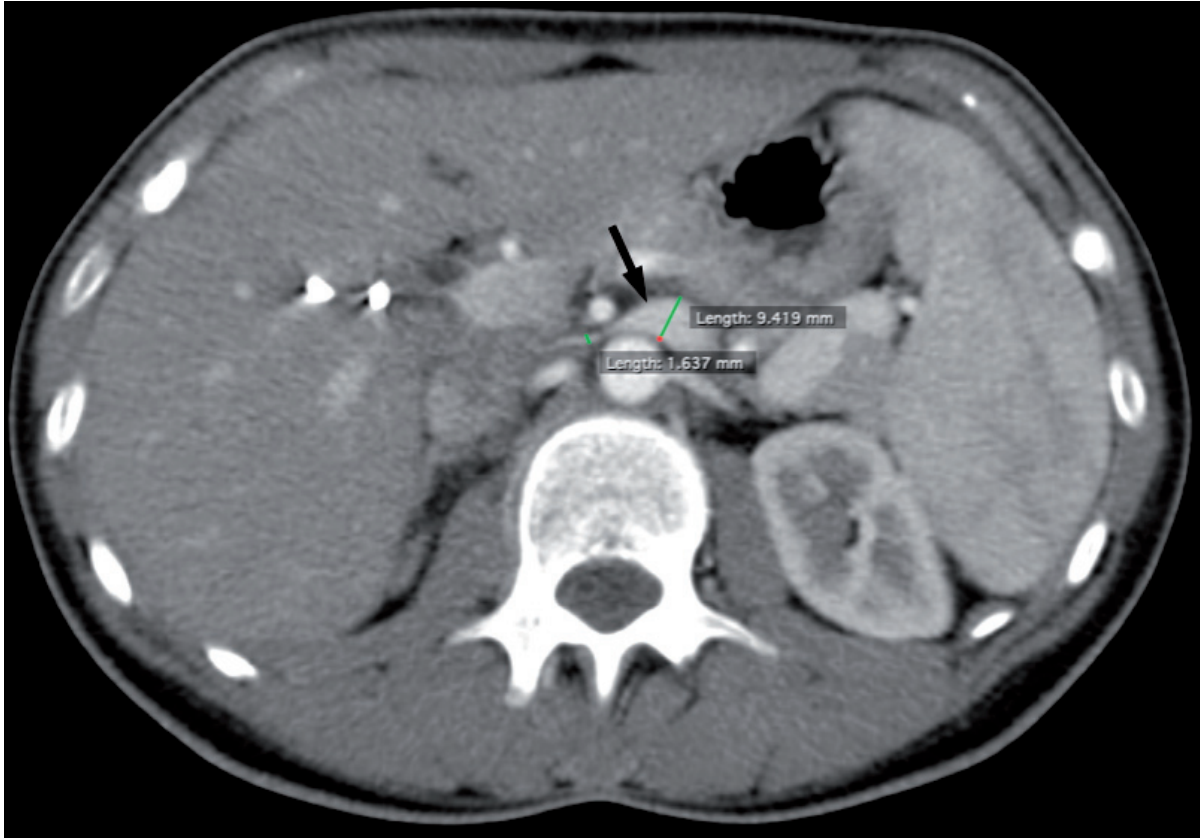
CT signs of NCS in a patient admitted to our department. The „beak sign“ (black arrow). LRV diameter ratio exceeding > 4.9 (5,75 in this patient)
